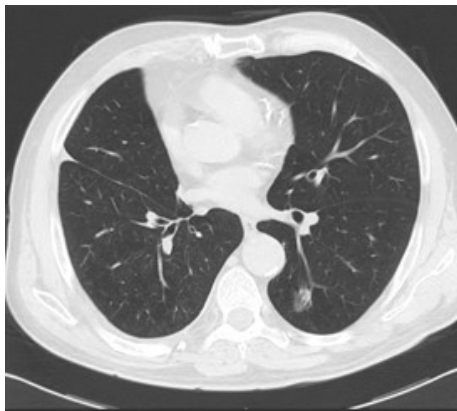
Computed tomography image of part solid ground-glass opacity (GGO).
